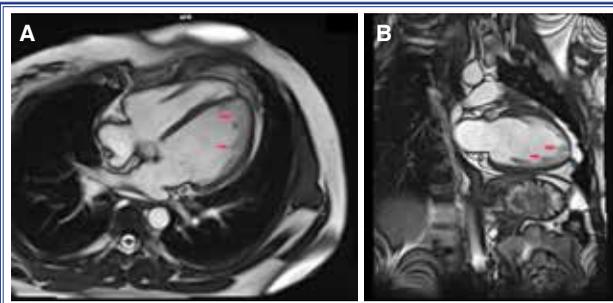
(A) Transverse cut view of MRI showing LVNC. (B) Coronal cut view of MRI showing LVNC.
